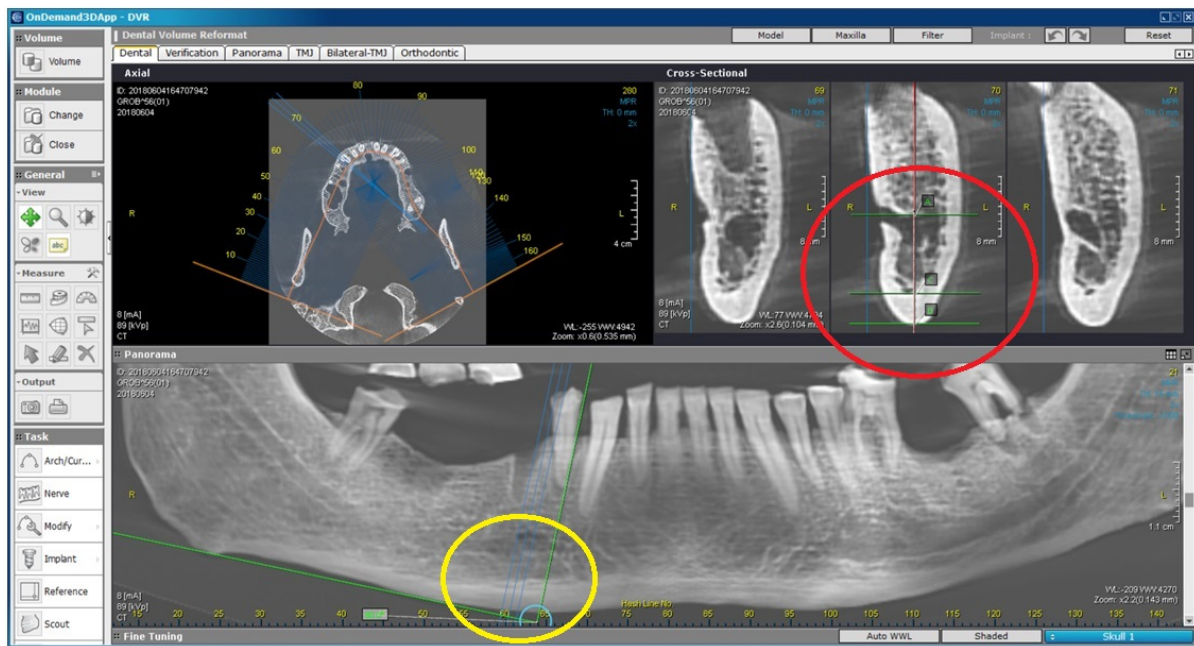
Measurement of the panoramic mandibular index (PMI) on the CBCT scan. The PMI was measured so that the line drawn in the panoramic projection was perpendicular to the inferior edge of the mandible and passed through the center of the mental foramen (circled in yellow). Then, the thickness of the mandibular cortex (BC) and the distance between the line passing through the center of the mental foramen and the inferior edge of the mandible (AB) were measured in the sagittal projection (circled in red). Finally, the ratio of the two assessments was determined as $PMI = BC/AB$.
